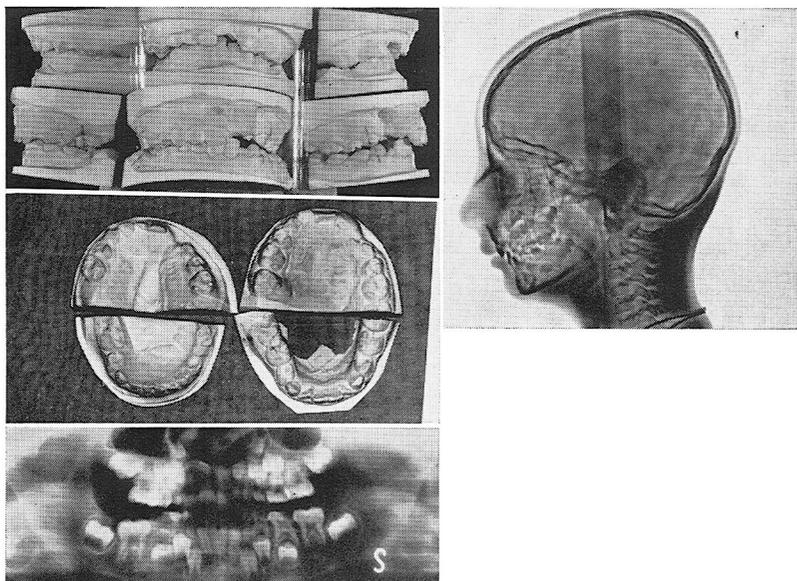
Unilateral left cleft lip and palate. At the time of the deciduous dentition the maxilla is very wide and covers the mandible. At the time of the mixed dentition period, this disproportionment is decreased, first as a consequence of scar contraction after surgical restoration of the palate, and second by the growth of the mandible, due to the orthodontic treatment. Teleradiography reveals good development of the maxilla, while the profile of the soft tissues and the occlusion reveal a second class. Panoramic radiography reveals that, as a consequence of the sagittal growth, the margins of the cleft are reduced.
